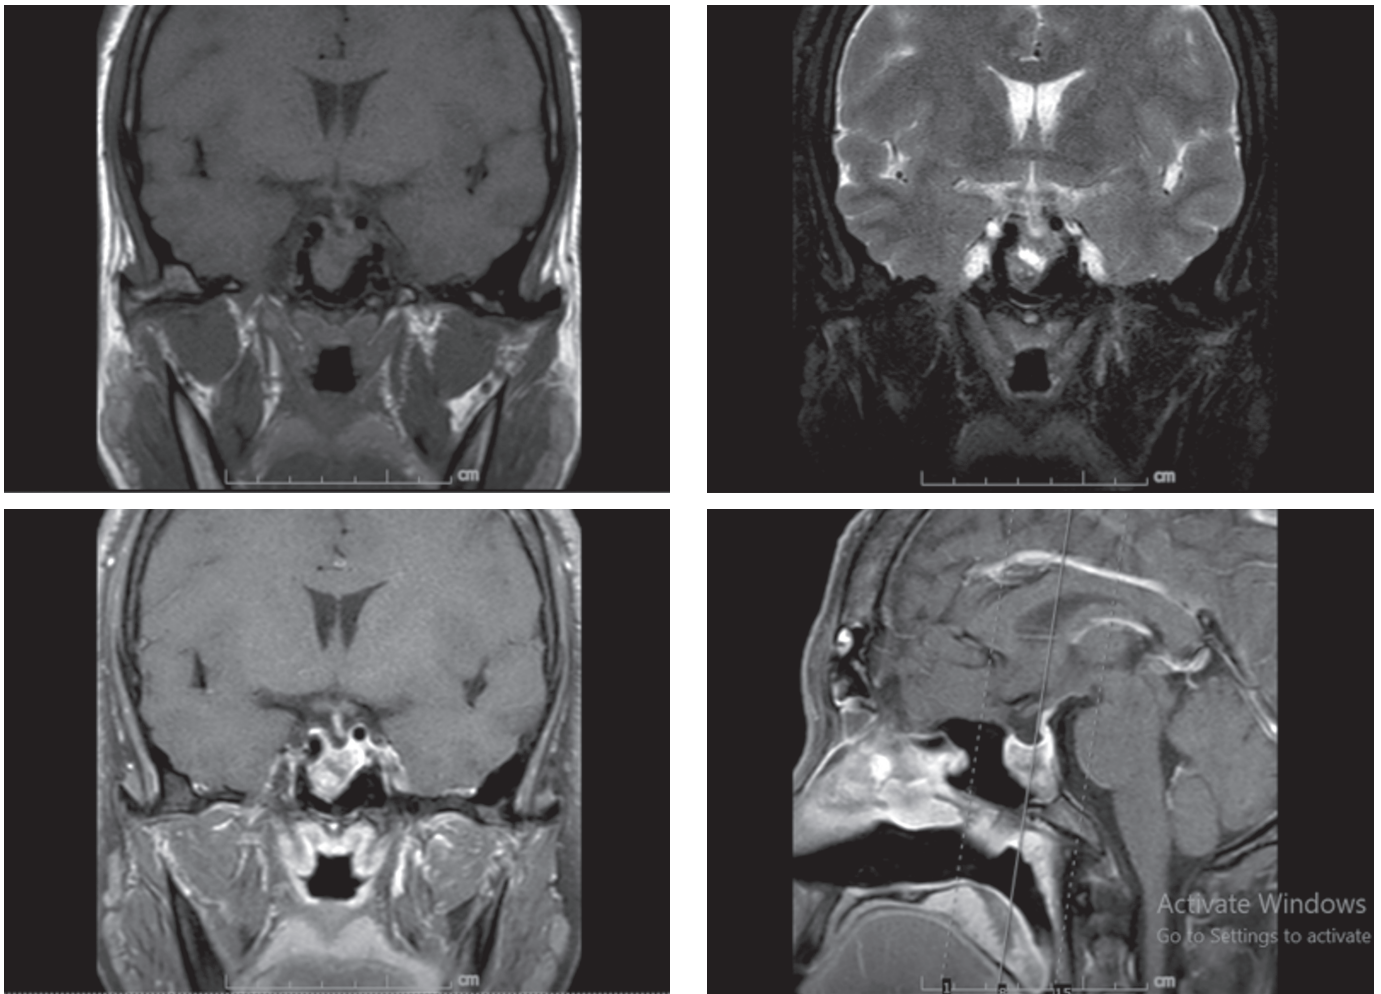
Pituitary MRI showing a heterogeneously enhancing intrasellar mass (1.7×1.9×1.9 cm) with inferior extension into the sphenoid sinus. Coronal views: (A) T1-weighted, (B) post-contrast T1-weighted, (C) T2-weighted; (D) sagittal view.
